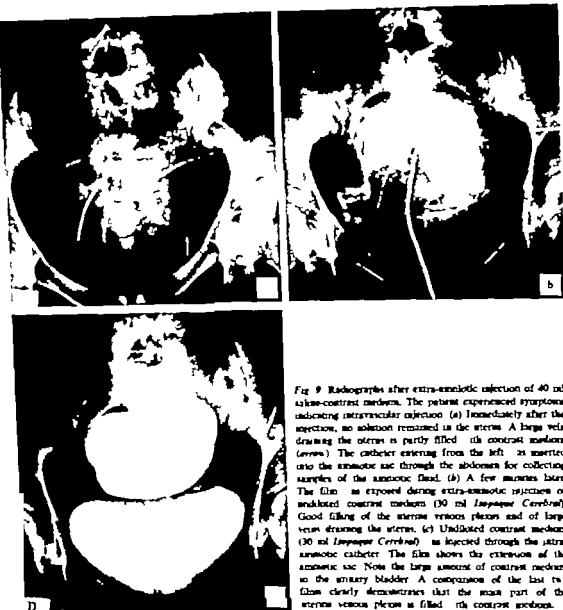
Radiographs after extra-amniotic injection of 40 ml saline-contrast medium. The patient experienced symptoms indicating intravascular injection. (a) Immediately after the injection, no solution remained in the uterus. A large vein draining the uterus is partly filled with contrast medium (arrows). The catheter entering from the left is inserted into the amniotic sac through the abdomen for collecting samples of the amniotic fluid. (b) A few minutes later, the film is exposed during extra-amniotic injection of undiluted contrast medium (30 ml *Iopaque Cerebral*). Good filling of the uterine venous plexus and of large veins draining the uterus. (c) Undiluted contrast medium (30 ml *Iopaque Cerebral*) is injected through the extra-amniotic catheter. The film shows the extension of the amniotic sac. Note the large amount of contrast medium in the urinary bladder. A comparison of the last two films clearly demonstrates that the main part of the uterine venous plexus is filled with contrast medium.
